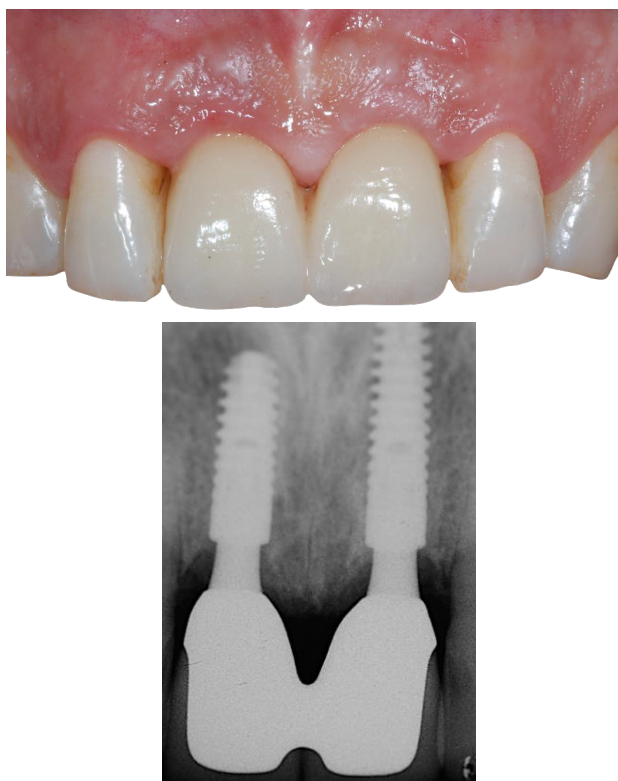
a): definitive crowns; b): periapical X-ray of the definitive crowns.
